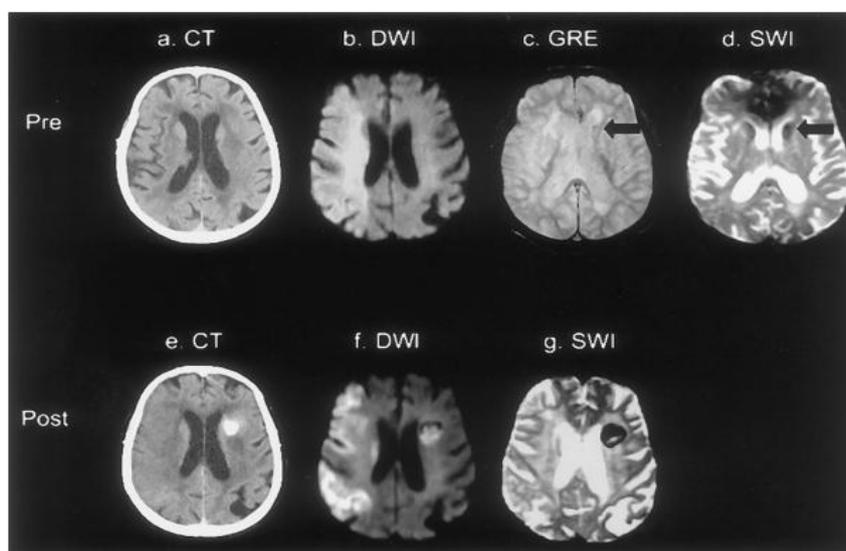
Pretreatment (top row) and post treatment (bottom row) imaging studies in a 96-year-old woman receiving intra-arterial thrombolysis for an acute right MCA occlusion. a, Pretreatment CT shows no evidence of acute or chronic hemorrhage and no hypodensity in right MCA territory. b, Pretreatment DWI study shows increased signal consistent with acute ischemia in right MCA territory. c, Pre- treatment SWI sequence shows hypointensity in left anterior periventricular region consistent with a previous silent microbleeds (arrow). d, Corresponding hypointense region on GRE sequence (arrow). e, Post treatment head CT shows hyperdensity consistent with acute blood in left anterior periventricular region occurring at site of old microbleeds. f, Post-treatment DWI shows evolution of infarction in right MCA territory. g, Post-treatment SWI shows hypointensity in right periventricular region corresponding to region of acute hemorrhage visualized on CT.
